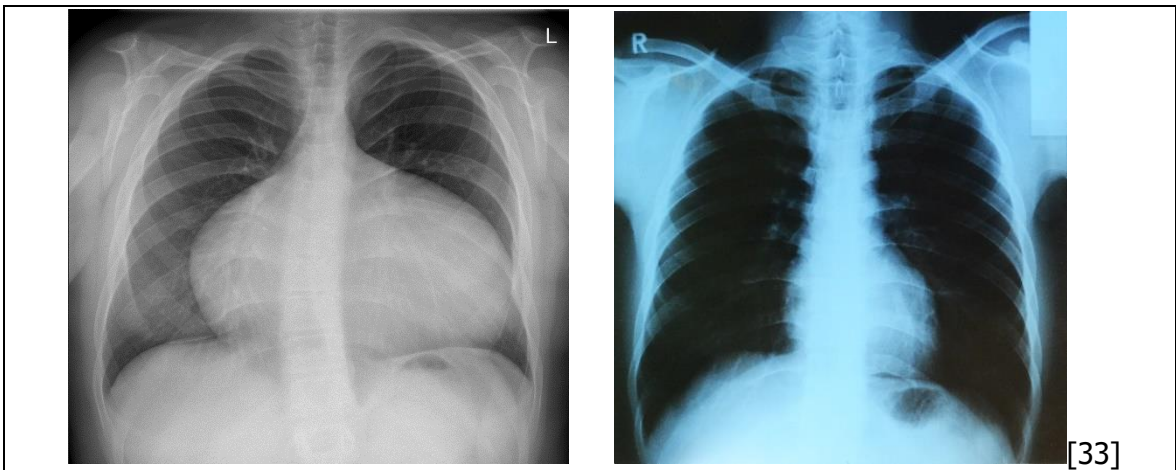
X-ray image in a patient with congenital heart defect and a healthy one
